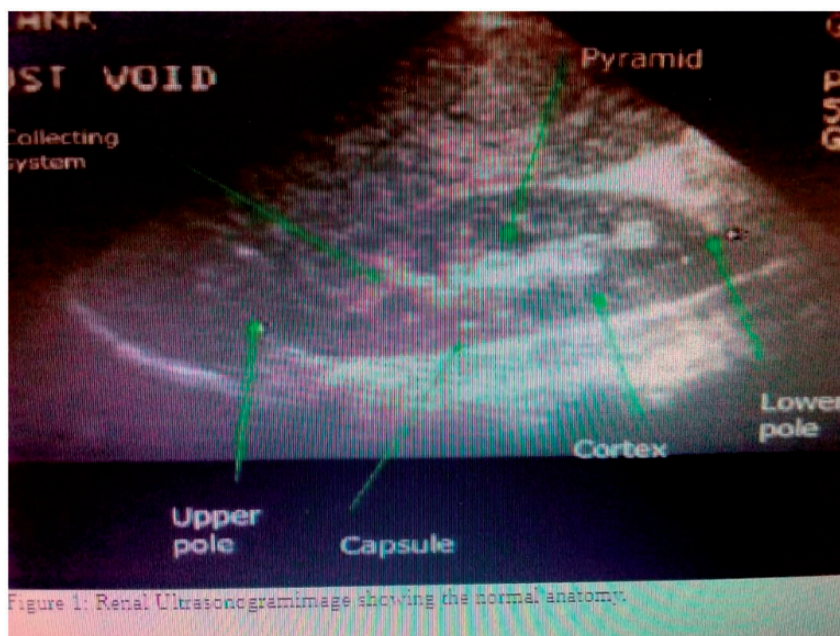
Renal ultrasonogram showing the normal anatomy.
